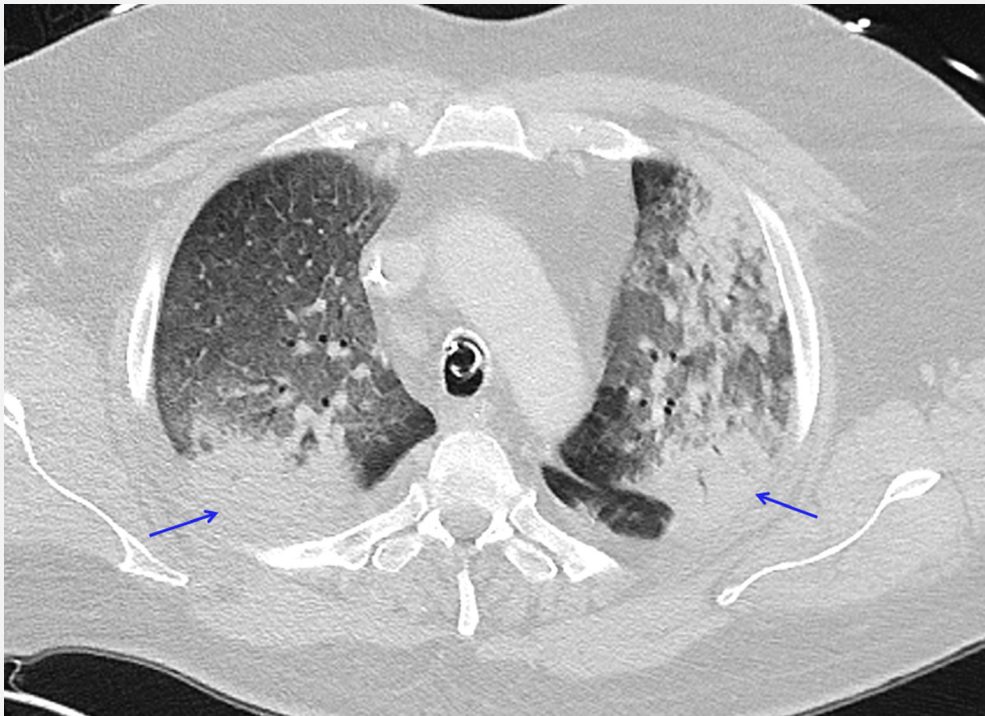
CT images in a 58-year-old man with COVID-19 pneumonia.
